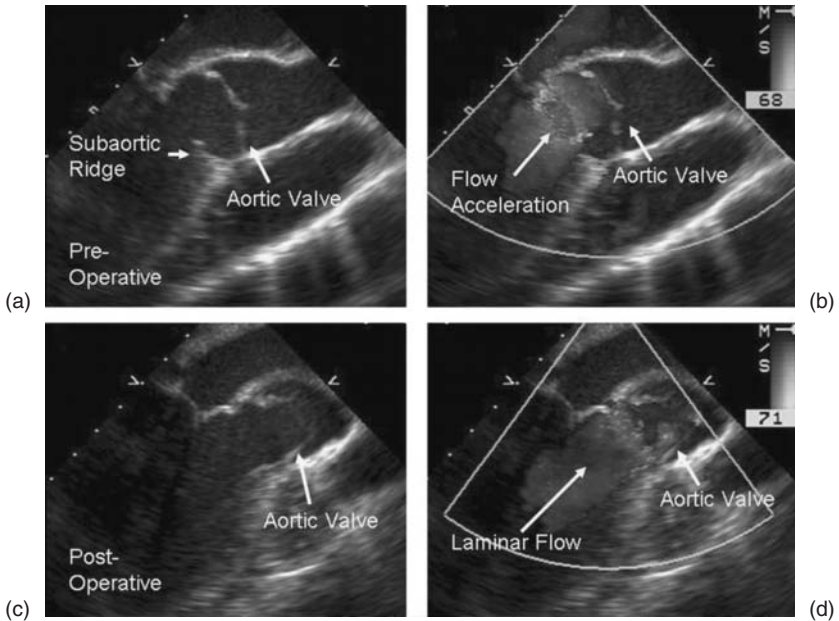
Transesophageal echocardiography (110-degree rotation) both before (a, b) and after (c, d) surgical resection of a subaortic ridge, shown without (a, c) and with (b, d) two-dimensional color Doppler. Preoperatively, there is a discrete ridge (a), and subvalvular flow acceleration is easily appreciated in early systole (b); note that the valve leaflets are just starting to open. Postoperatively, the membrane has been removed (c), and laminar flow through the LVOT has been restored (shown at midsystole; d).
